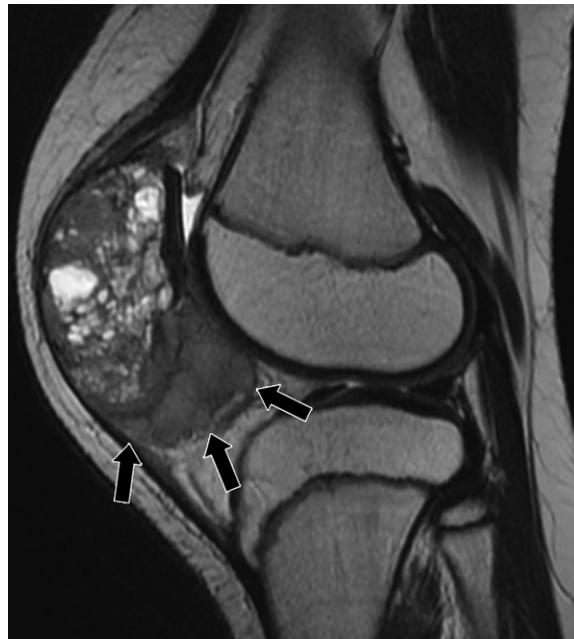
Giant cell tumor of the patella in a 10-year-old girl with a history of anterior knee pain. She was found to have a lytic lesion at radiography and was referred for MRI. Sagittal T2-weighted MR image shows an expansile heterogeneous tumor replacing the patella. There is soft-tissue extension of the tumor into the upper edge of the Hoffa fat pad (arrows). Biopsy demonstrated giant cell tumor. (Courtesy of Shelly Marette, MD, University of Minnesota, Minneapolis, Minn.)
